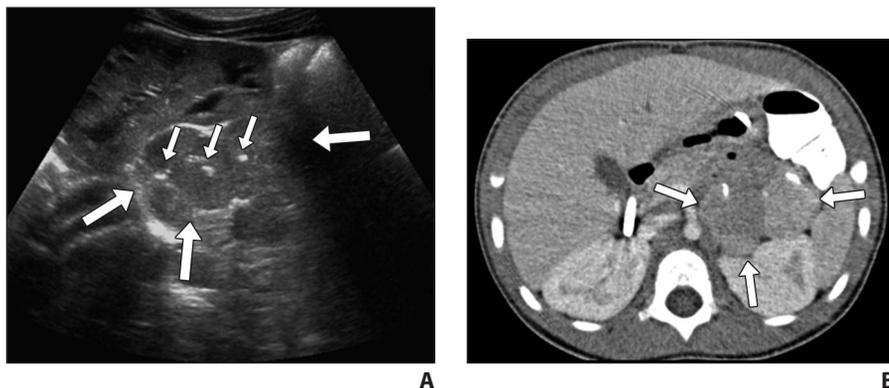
14-month-old girl with Li-Fraumeni syndrome. A, Screening gray-scale ultrasound image of left kidney shows abnormal lobulated retroperitoneal mass (*large arrows*) adjacent to kidney hilum and calcifications within mass (*small arrows*). At physical examination, clinicians noted virilization (new from prior examination). B, Axial contrast-enhanced CT image of abdomen at level of kidneys shows lobulated solid mass with coarse calcifications (*arrows*). Normal left adrenal gland was not identified. Biopsy result was adrenocortical carcinoma.
